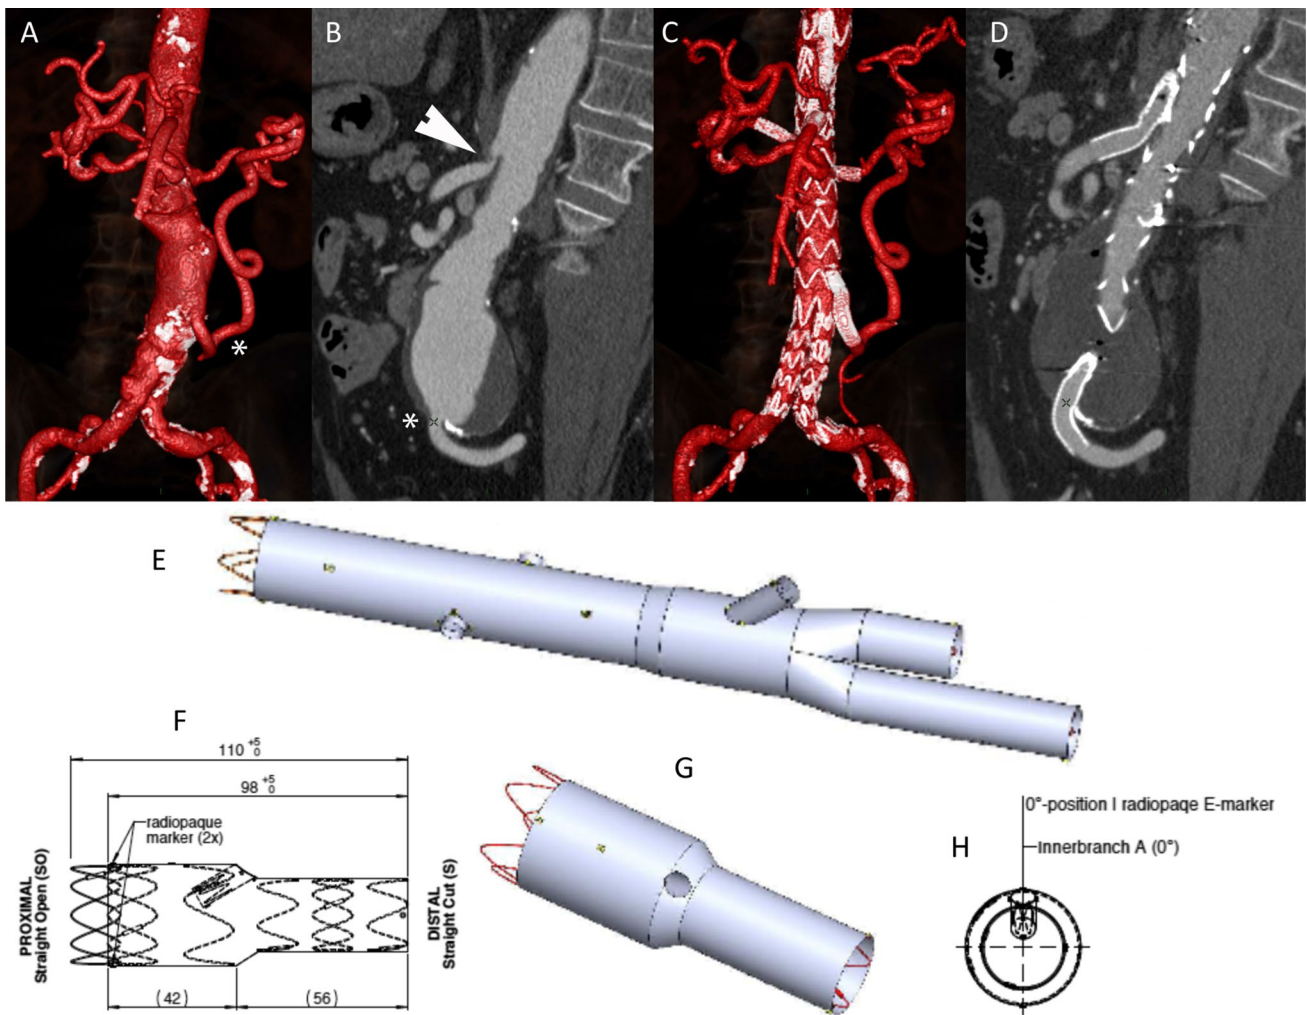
Clinical case of a 67-year-old male patient with a 52-mm Crawford type 4 aneurysm. A Pre-procedural CT angiography (CTA) volume rendering (VR) reconstruction shows that the aneurysm involved the splanchnic vessels and depicts a hypertrophied inferior mesenteric artery (IMA; asterisk). B Oblique multi-planar reconstruction (MPR) confirms an occluded coeliac trunk, a pre-occlusive stenosis of the superior mesenteric artery (SMA; arrowhead) and a
